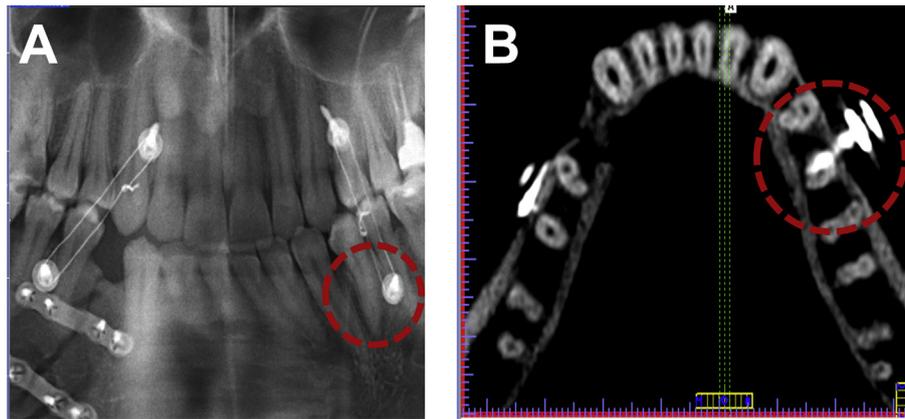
Exemplary OPTG (A) and CBCT (B) scans with a tooth root injury (grade 3) of the second premolar of the left lower jaw (red circles). The OPTG scan (A) only allows the presumption of a tooth root injury. The CBCT scan (B) enables the reliable diagnosis of the tooth root injury, and further, a severity assessment.
